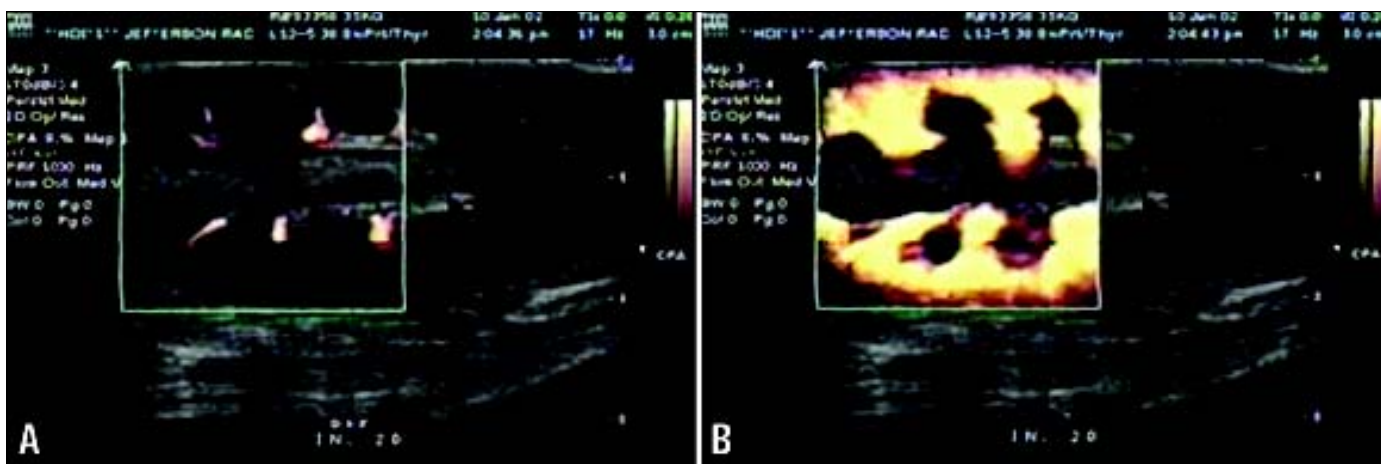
PLGA (50:50) contrast agent injected into a rabbit kidney and imaged in Power Doppler mode (Courtesy of Thomas Jefferson University, Department of Radiology). The Doppler image is inside the box and shows parenchymal enhancement. A) pre-injection, B) Post injection (0.15ml/kg (2.42 x 10⁻⁶ ft³)).
